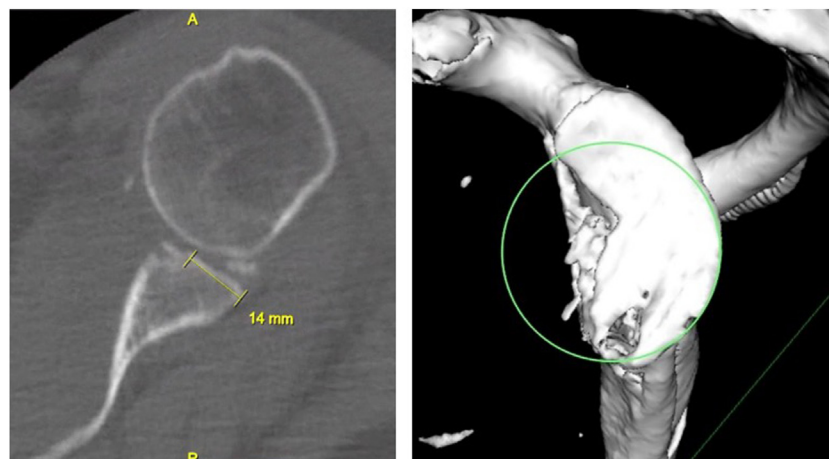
Preoperative CT scan and 3D reconstruction post first closed reduction identifying anterior bone loss Green circle is the best fitting circle, a measurement technique to identify relative glenoid bone loss area. CT, computed tomography.
